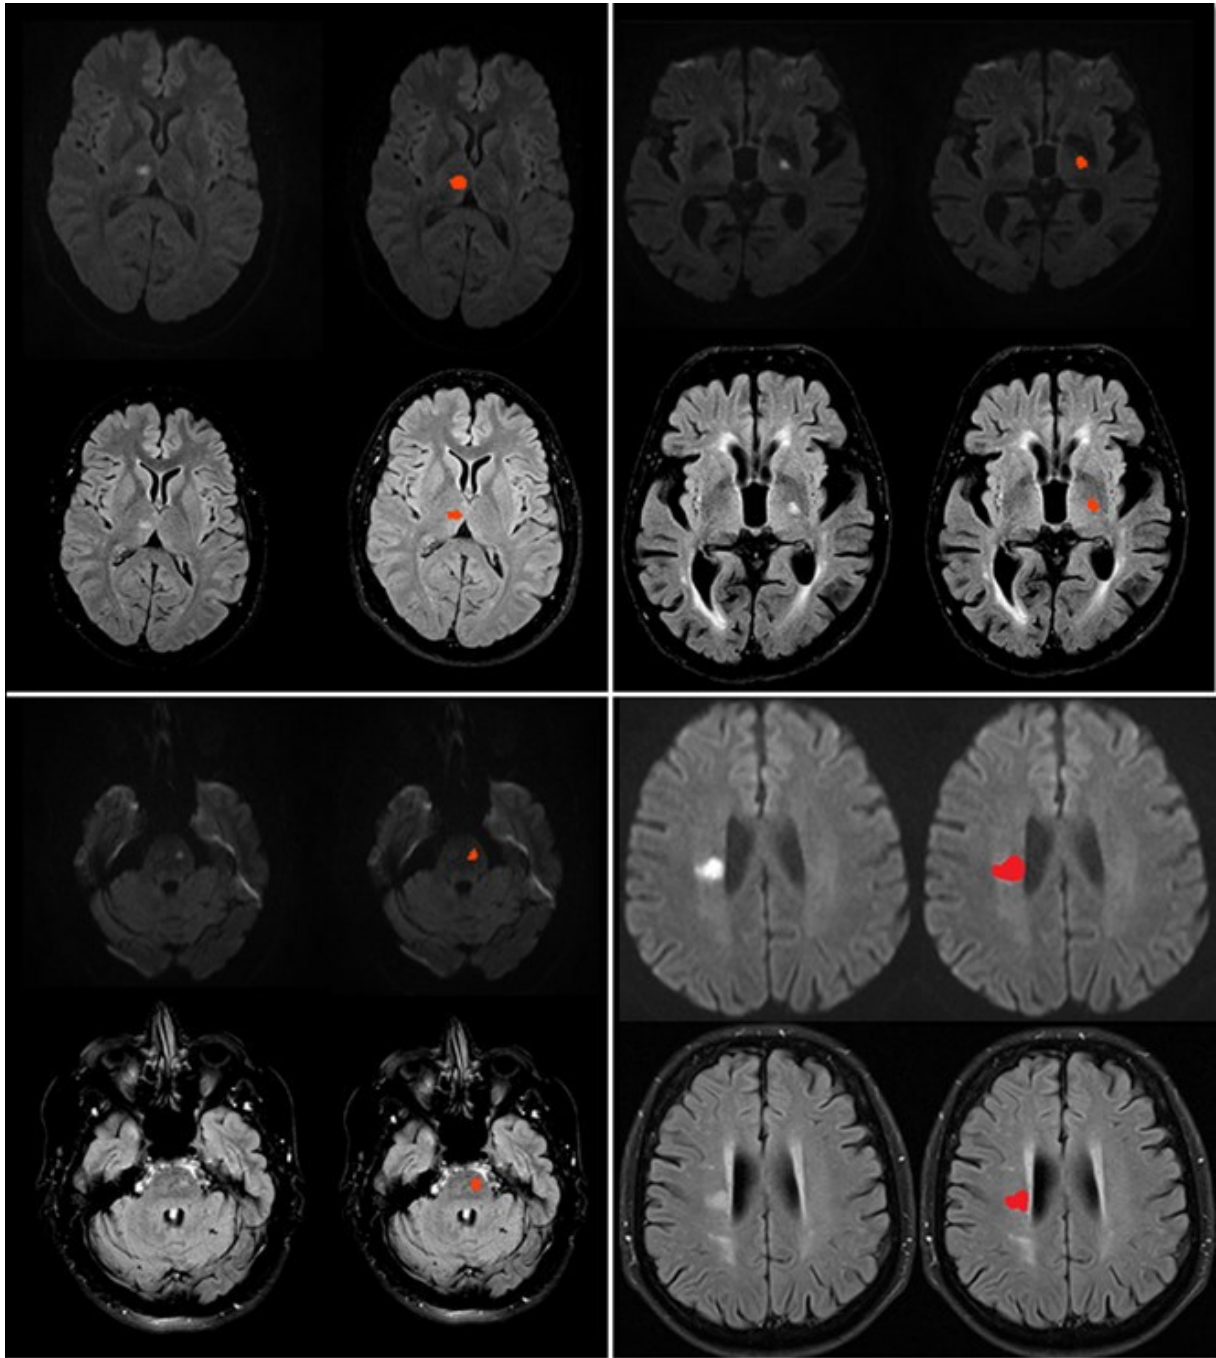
Examples of acute subcortical (lacunar) infarcts in four different and typical localizations (A. thalamus, B. pons, C. internal capsule and D. centrum semiovale) on DWI and FLAIR- weighted MRI scans.
